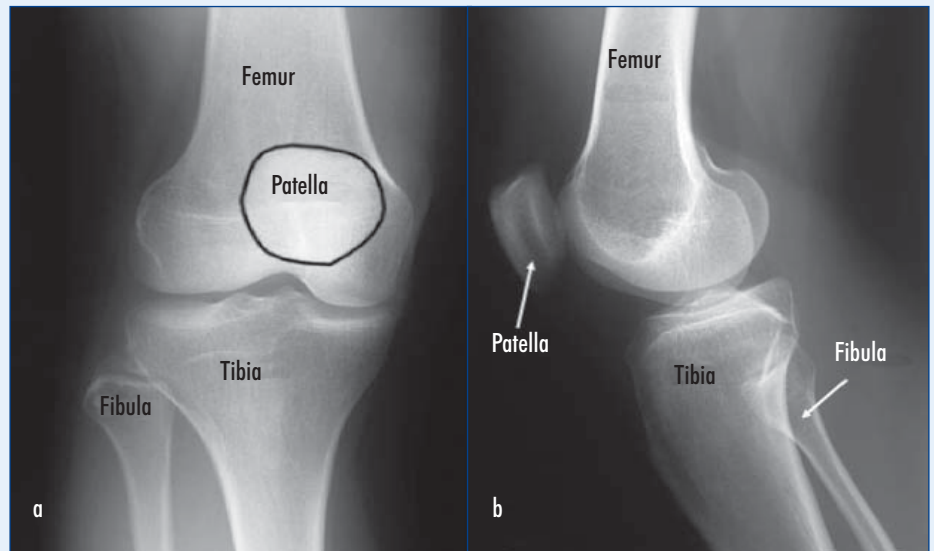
Bony anatomy of the knee joint. a. Anteroposterior and (b) lateral radiographs.
